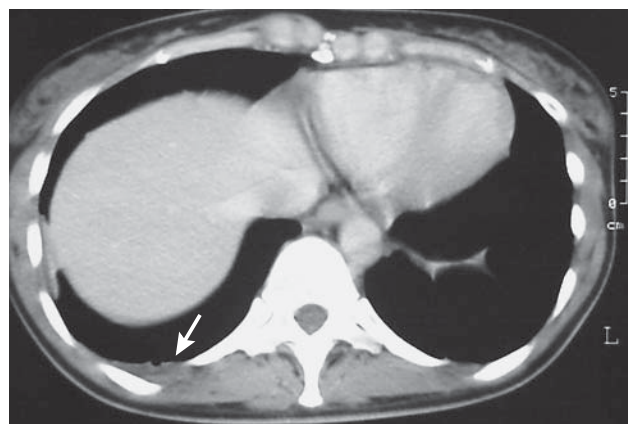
Non-contrast chest computed tomography scan image reveals a small pleural effusion in the right thoracic cavity (arrow).
